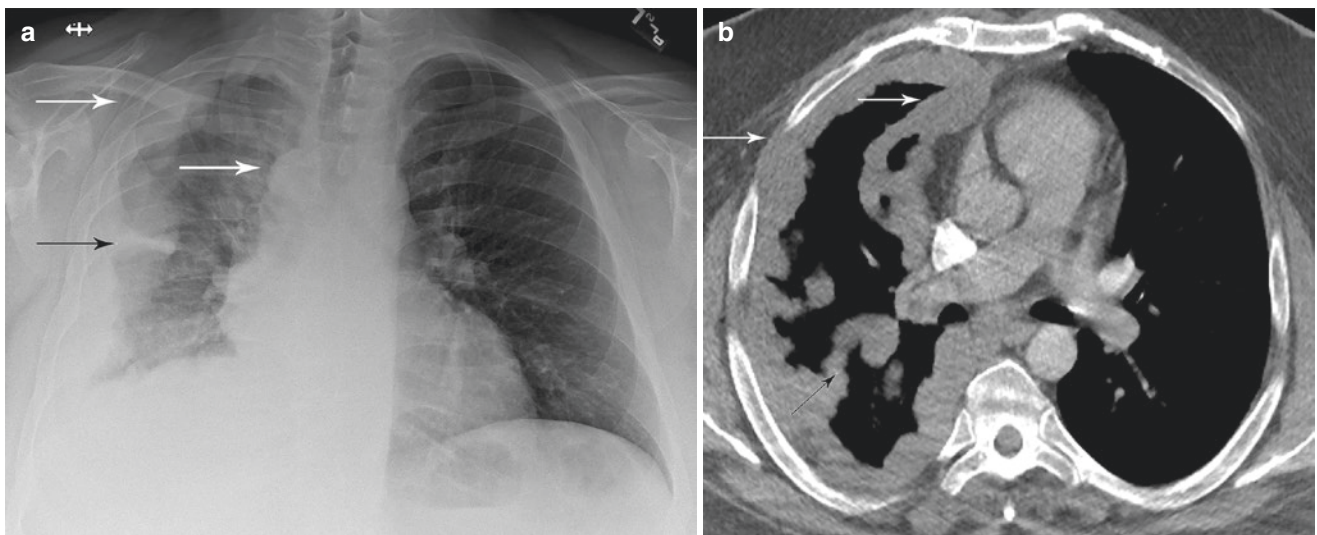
(a) Frontal chest radiograph shows the features of malignant pleural disease, with a right nodular pleural rind of tumor encasing the right lung (white arrows). There is involvement of the minor fissure
